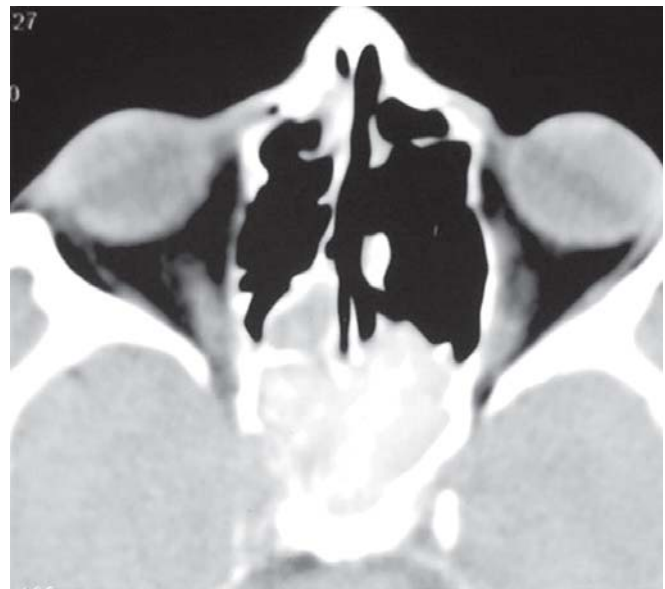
Preoperative, poststeroid axial CT – PNS of the same patient (Fig. 4) showing a dramatic reduction in the bulk of disease
